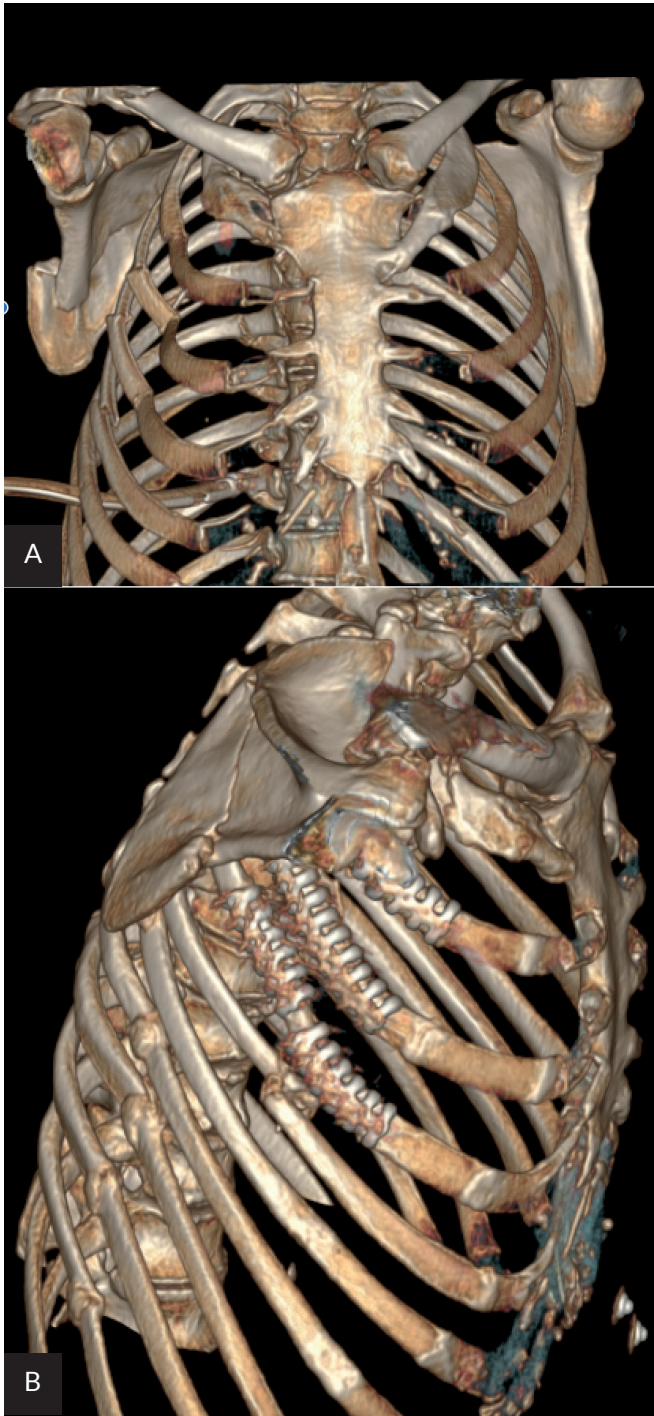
Case 3. Computed tomography findings. A. Preoperatively. B. Postoperatively
